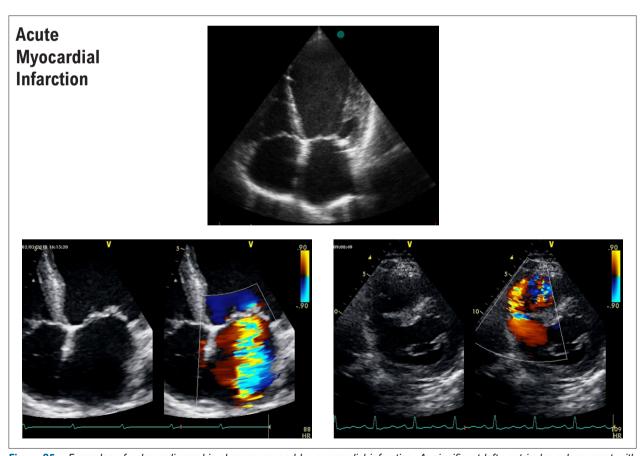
Examples of echocardiographic changes caused by myocardial infarction. A: significant left ventricular enlargement with spontaneous echo contrast; B: severe mitral regurgitation secondary to papillary muscle ischemia; C: post-MI ventricular septal defect. Note left-to-right shunting in red.
